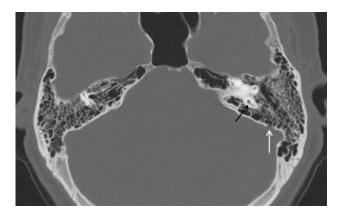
Subject 24. Axial CT scan at the level of the common crus (black arrow) shows a small bone defect caused by presumed AG (white arrow), located at the lateral third of the posterior wall of left temporal bone. Although a focal loss of the posterior wall of the mastoid air cells is also present, there is no evidence of tympanomastoid opacification. This 66-year-old woman presented with hemifacial spasm, and there was no clinical feature suggesting CSF leakage.
